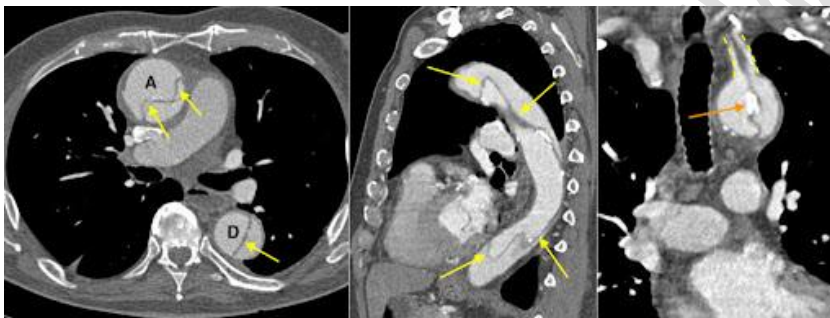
CT of Aortic Dissection (11)
